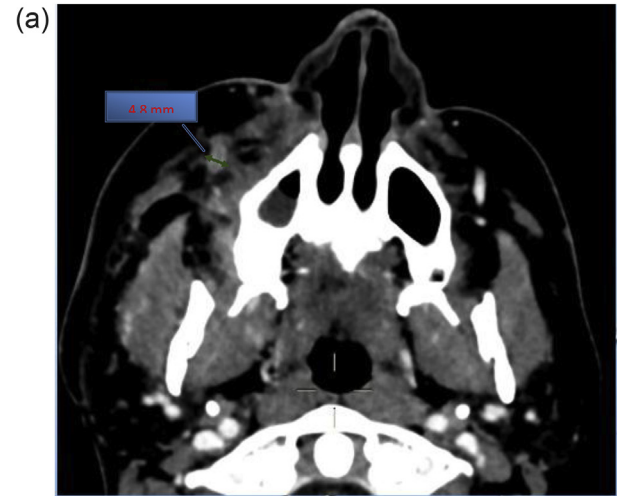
a Contrast enhanced CT at hospitalization. Diameter of the facial vein distal to the thrombus is 4.8 mm. b Contrast enhanced CT 1 month post discharge. Diameter of facial vein in its distal area after thrombus resolution is 2.4 mm.
